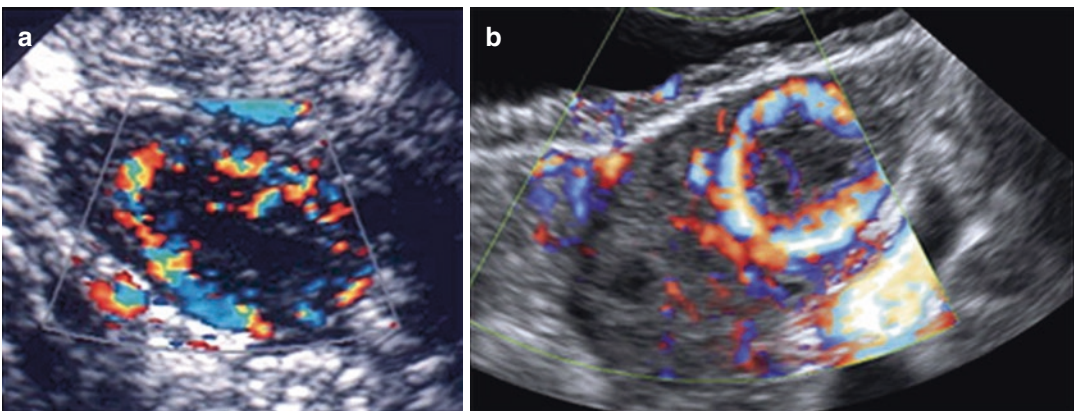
Corpus luteum ultrasound study. (a) Note the irregular cystic mass with crenulated borders and low-level echoes. (b) Doppler findings of a hypervascular corpus luteum with low resistance index
